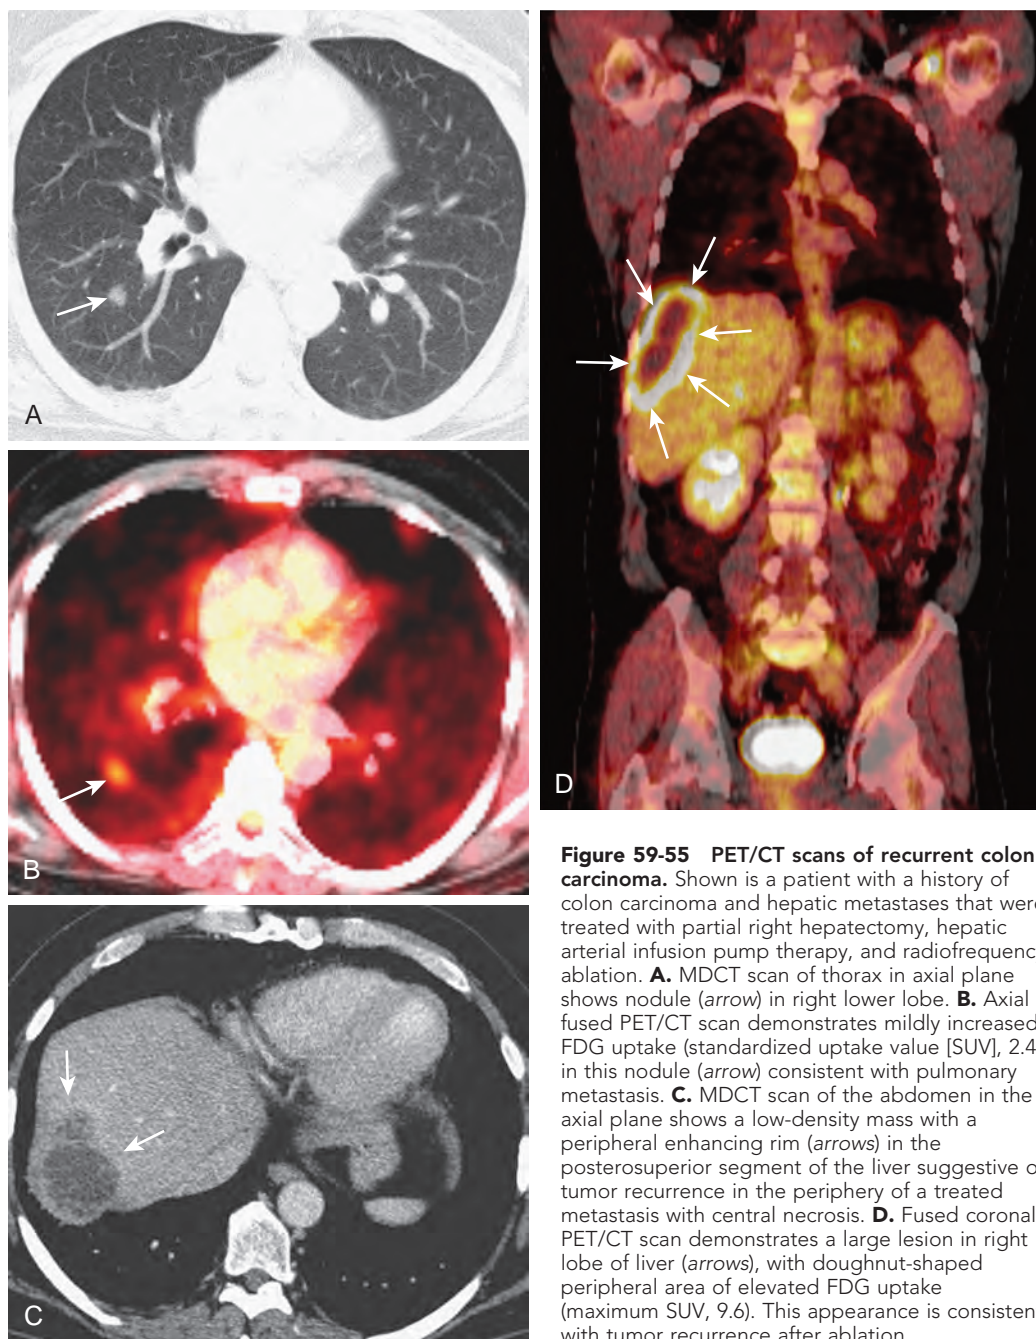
PET/CT scans of recurrent colon carcinoma. Shown is a patient with a history of colon carcinoma and hepatic metastases that were treated with partial right hepatectomy, hepatic arterial infusion pump therapy, and radiofrequency ablation. A. MDCT scan of thorax in axial plane shows nodule (arrow) in right lower lobe. B. Axial fused PET/CT scan demonstrates mildly increased FDG uptake (standardized uptake value [SUV], 2.4) in this nodule (arrow) consistent with pulmonary metastasis. C. MDCT scan of the abdomen in the axial plane shows a low-density mass with a peripheral enhancing rim (arrows) in the posterosuperior segment of the liver suggestive of tumor recurrence in the periphery of a treated metastasis with central necrosis. D. Fused coronal PET/CT scan demonstrates a large lesion in right lobe of liver (arrows), with doughnut-shaped peripheral area of elevated FDG uptake (maximum SUV, 9.6). This appearance is consistent with tumor recurrence after ablation.
